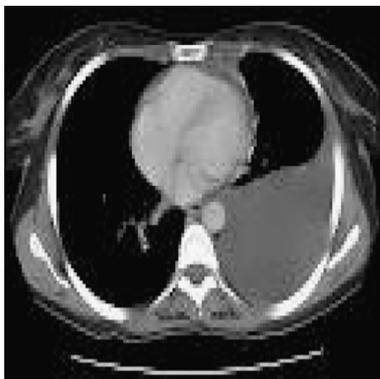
CT showing moderate to massive pleural effusion with no evident pleural thickening or masses.
